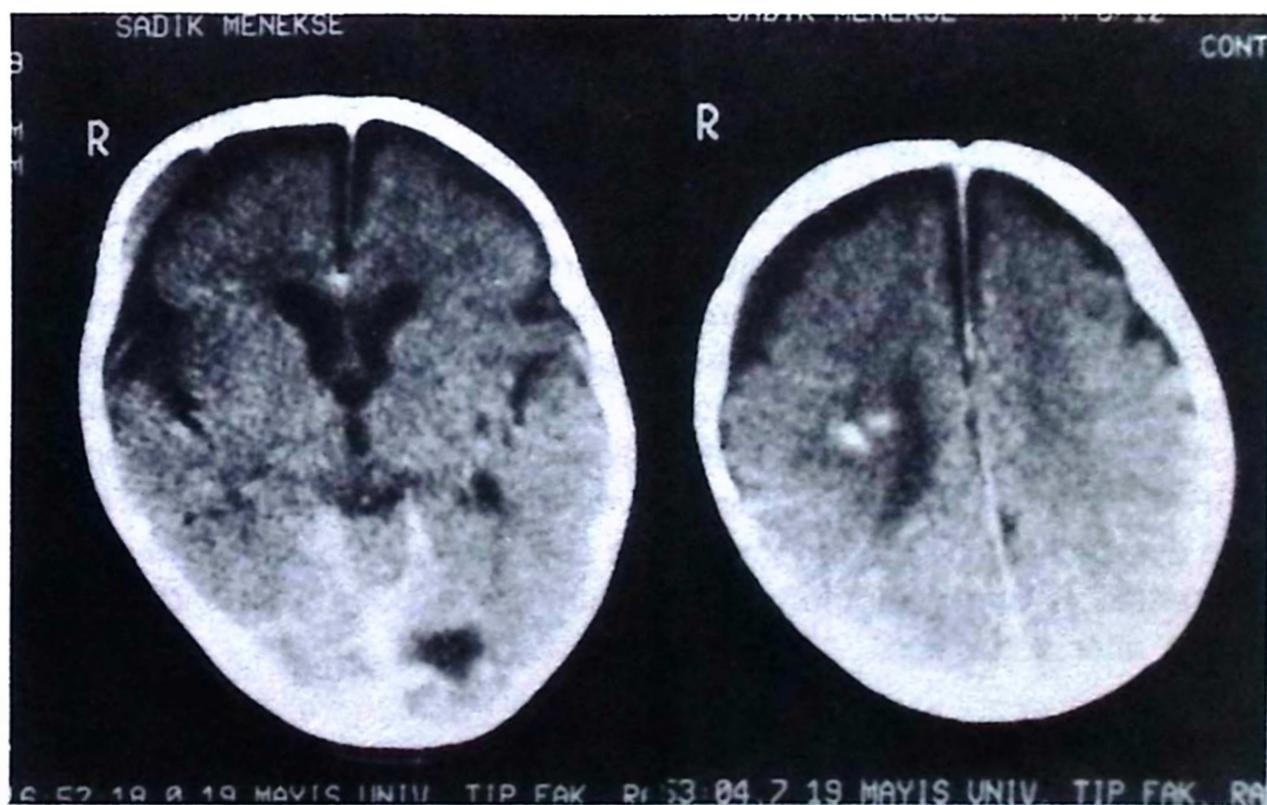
Post-contrast CT at five months, demonstrating small hyperdense lesions in the right paraventricular white matter, encephalomalacic focus in the left occipital lobe, and minimal subdural effusion (Case 1).
